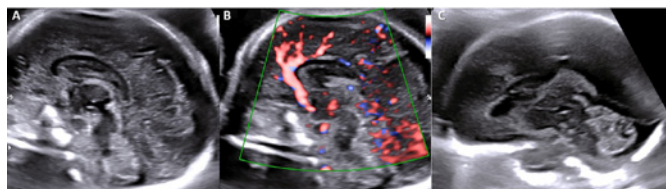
A. Median sagittal image of the cephalic pole showing the absence of the cavum septum pellucidum. B. Color Doppler showing the pericalosal artery.
